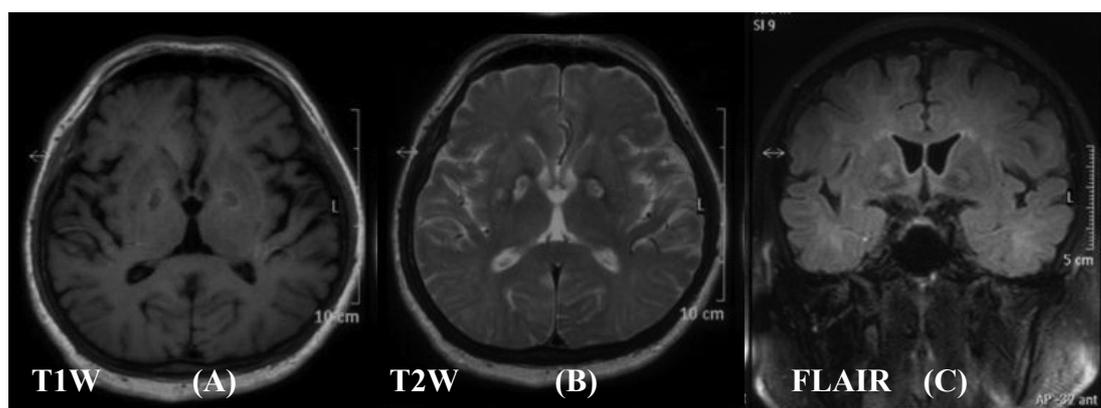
Non-contrasted 1.5-Tesla brain MRI axial T1 (A) and T2-weighted (B) sequences and coronal FLAIR (C) performed three weeks after the initial presentation, showing hyperintense lesions of the globus pallidus on T2-weighted sequence (hypointense on T1 sequence), and diffuse cerebral white matter signal change, without contrast enhancement.
